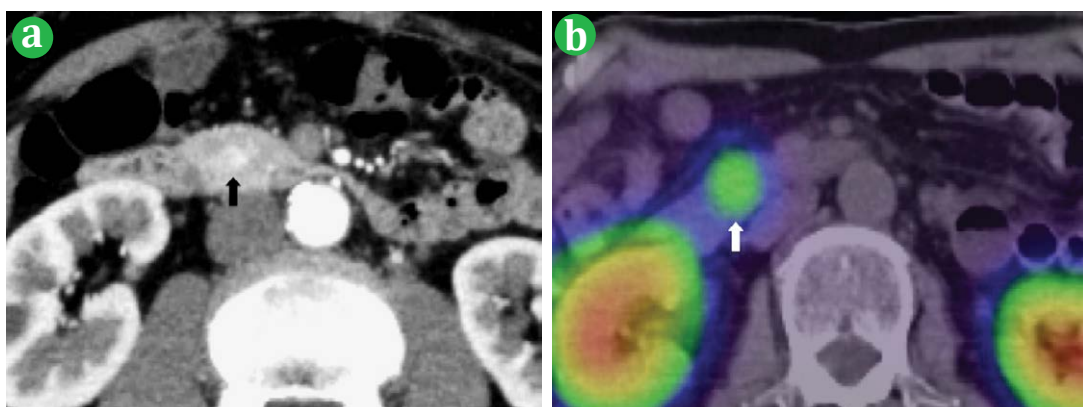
Tumor detected by somatostatin analogue scintigraphy (Insulinoma, G1). (a). Dynamic computed tomography scan shows a hypervascular mass. (b). 111In-pentetreotide single photon emission tomography (Octreoscan) shows high uptake of somatostatin analogue in pancreas lesions.
